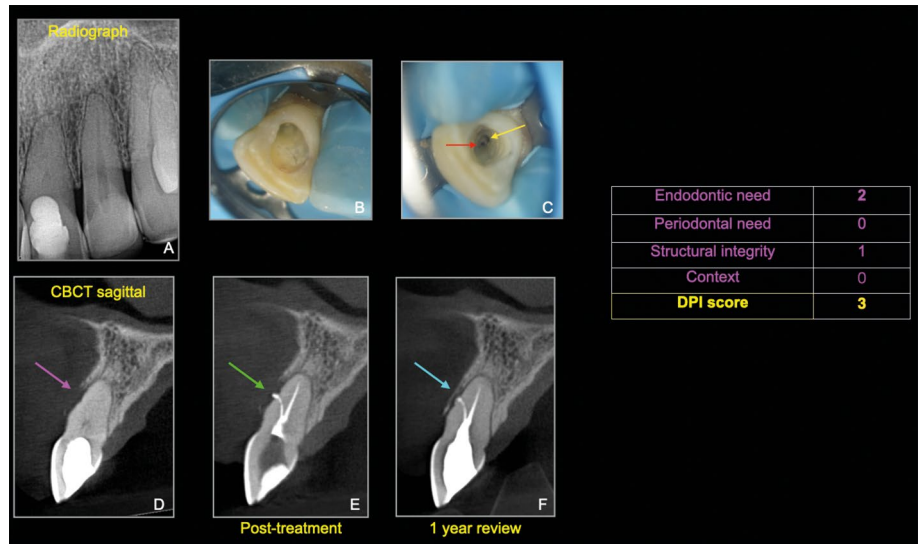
Root canal treatment of a symptomatic 21 attempted by a dentist who aborted treatment as the canal could not be identified. The patient was advised that the tooth had a poor prognosis and extraction and replacement with an implant-retained crown should be considered. The patient sought the opinion of an endodontist who assessed and managed the tooth. a) Periapical radiograph reveals attempted root canal treatment and a sclerosed root canal(s). b, c) Clinical assessment reveals sufficient sound tooth structure and two canals (red and yellow arrows). d) CBCT sagittal slice reveals a second root canal exiting onto labial aspect (purple arrow) of the tooth. e) Post-treatment CBCT (sagittal) confirms root fillings are to length (green arrow). f) One-year follow-up scan confirms significant healing (compare purple and blue arrows)
